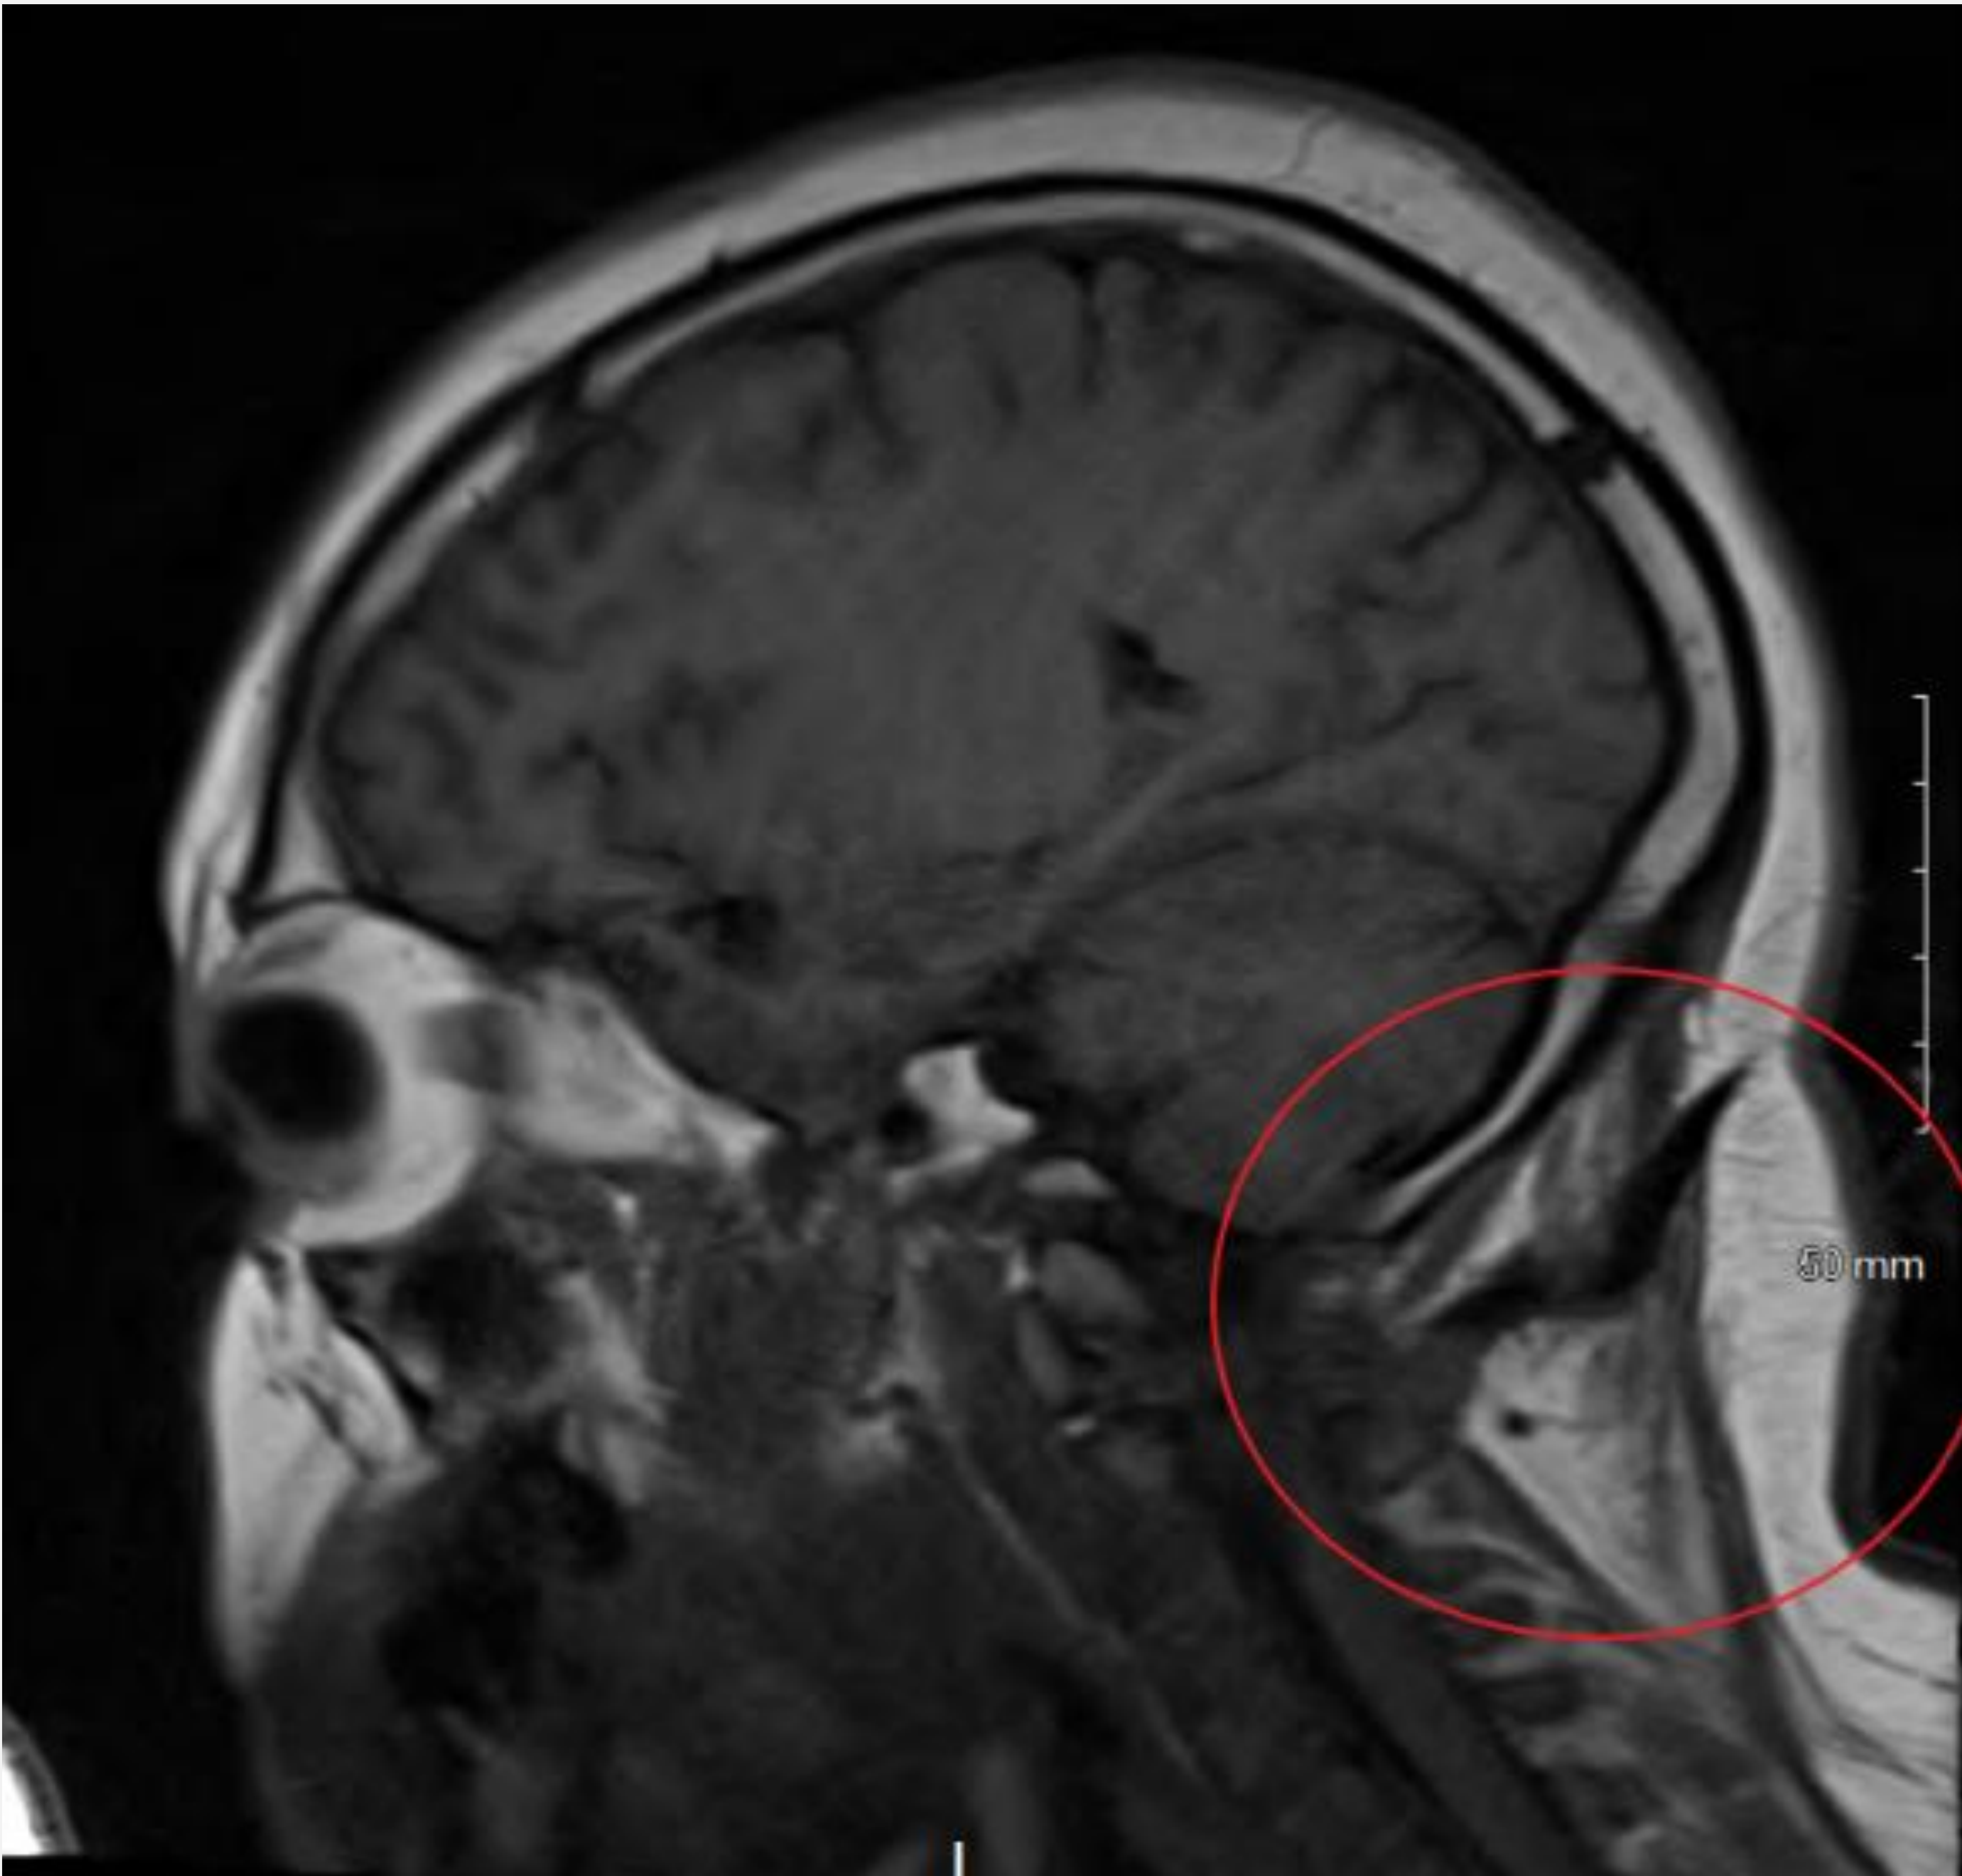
Cervical spine MRI showing a spinocutaneous CSF fistula
